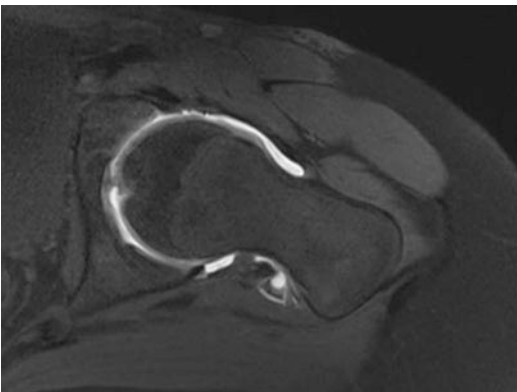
Axial MRI of hip demonstrates lateral extension of capital physeal scar in the anterosuperior femoral head associated with a cam deformity
